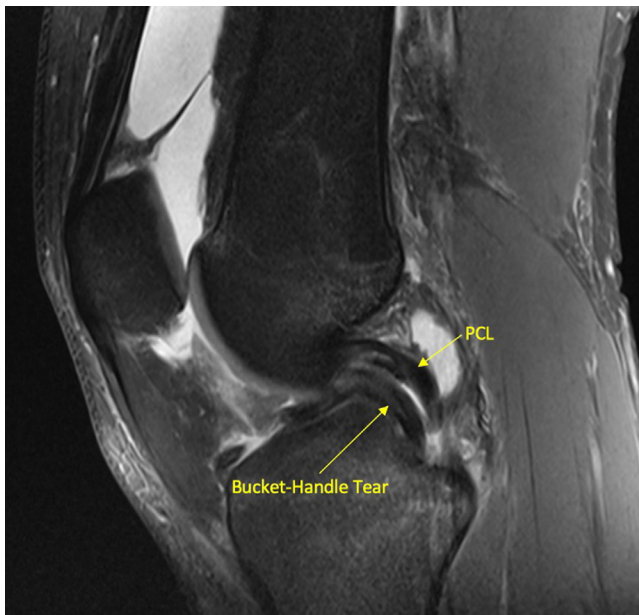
Magnetic resonance imaging of a right knee sagittal section, in the proton density fat-saturated sequence, demonstrating a “double posterior cruciate ligament” sign with a hypointense, arciform band indicative of a medial meniscus bucket-handle tear with a flipped meniscal fragment within the intercondylar notch. (PCL, posterior cruciate ligament.)
